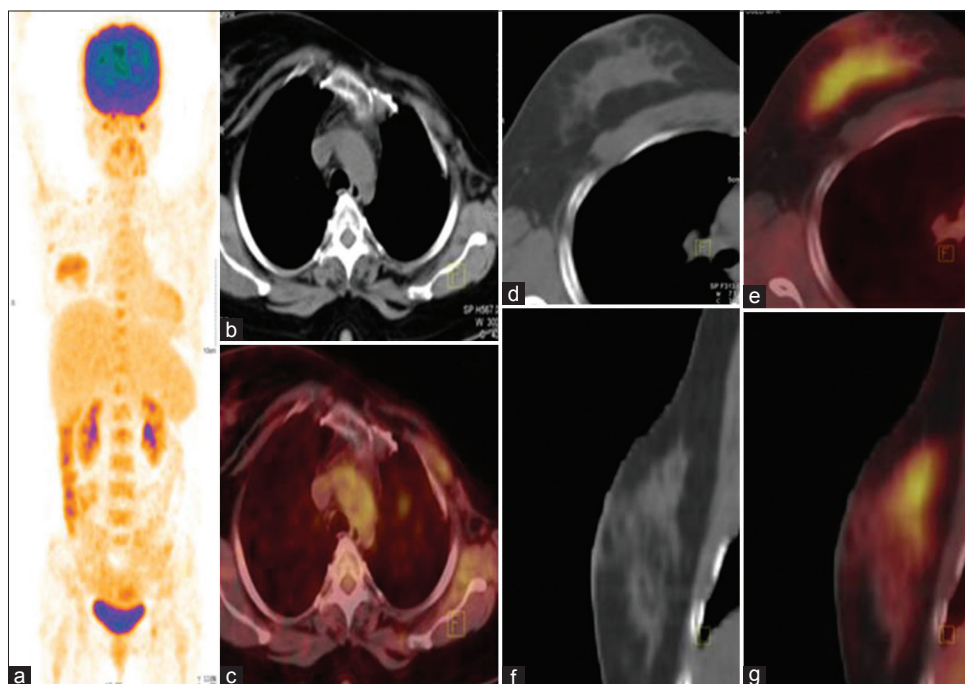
Representative case for true-positive 1: A 39-year-old female, a known case of carcinoma left breast (ER and PR positive, and Her-2neu negative), postneoadjuvant chemotherapy, left modified radical mastectomy, and four cycles of chemotherapy with AC regimen, on regular follow-up, was diagnosed with a metabolically active soft-tissue density lesion in the right breast. (a) MIP image, (b-g) computerized tomography and positron emission tomography–computerized tomography-fused images of the right breast. Positron emission tomography–computerized tomography-based ultrasound-guided biopsy was taken from the lesion, which came out to be infiltrating duct cell carcinoma (triple-positive)
